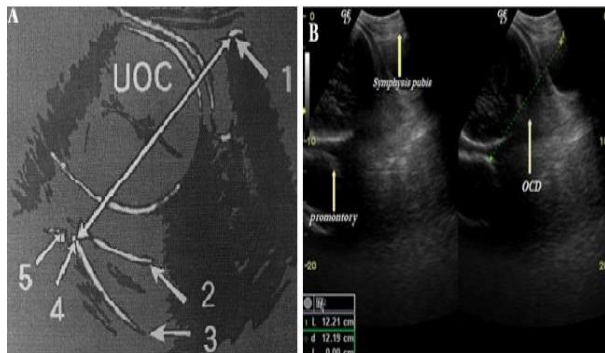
A (sonographic) and B (Ultrasound) pictures showing the measure of obstetric conjugate diameter (OCD). (1: Pubic bone, 4: sacral Promontory, 5).¹²
